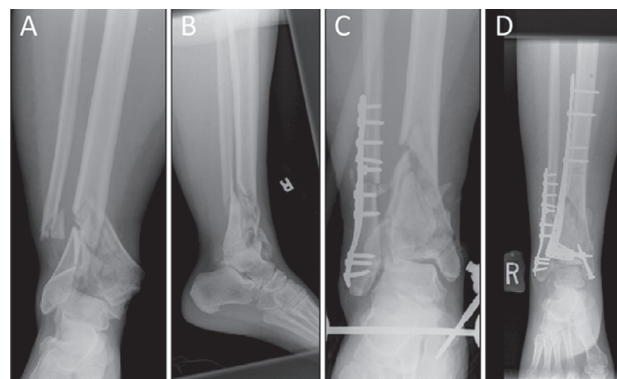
Radiographs of a pilon fracture. Anterior posterior view (A) and lateral view (B) of the patient on initial presentation to emergency department. The fibular fracture was fixed and an external fixator was placed (C), and then the patient was taken to the operating room 10 days later for definitive fixation of the tibia (D).
